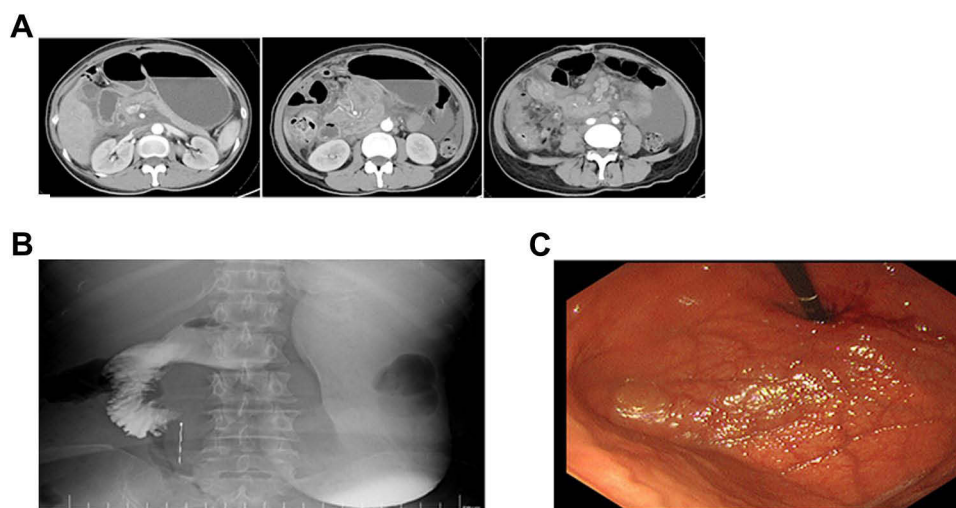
Radiological imaging studies and electronic gastroduodenoscopy showing progression of disease. (A) CT scan revealed that the gallbladder tumor lesion was larger than before and more lymph node metastases. (B) Upper gastrointestinal radiography showed obstruction at the origin of the horizontal part of the duodenum. (C) Electronic gastroduodenoscopy showed stenosis of the horizontal transition of the duodenum.
